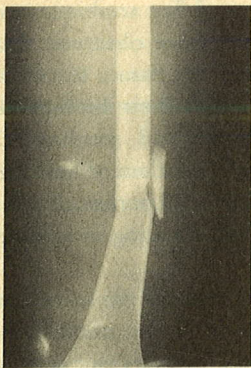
Pre-operative radiograph of fracture shaft of femur with Gr.III comminution.
